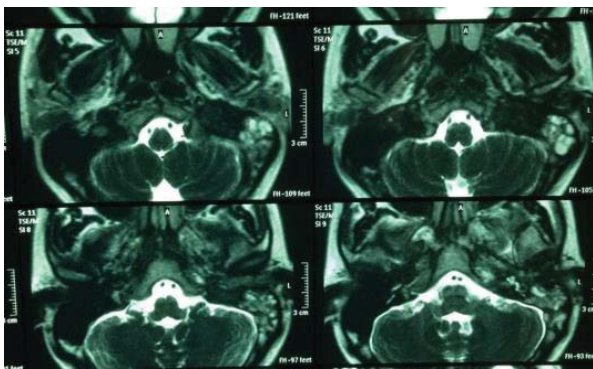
MRI showing the mass in the middle ear with erosion of surrounding bone.
